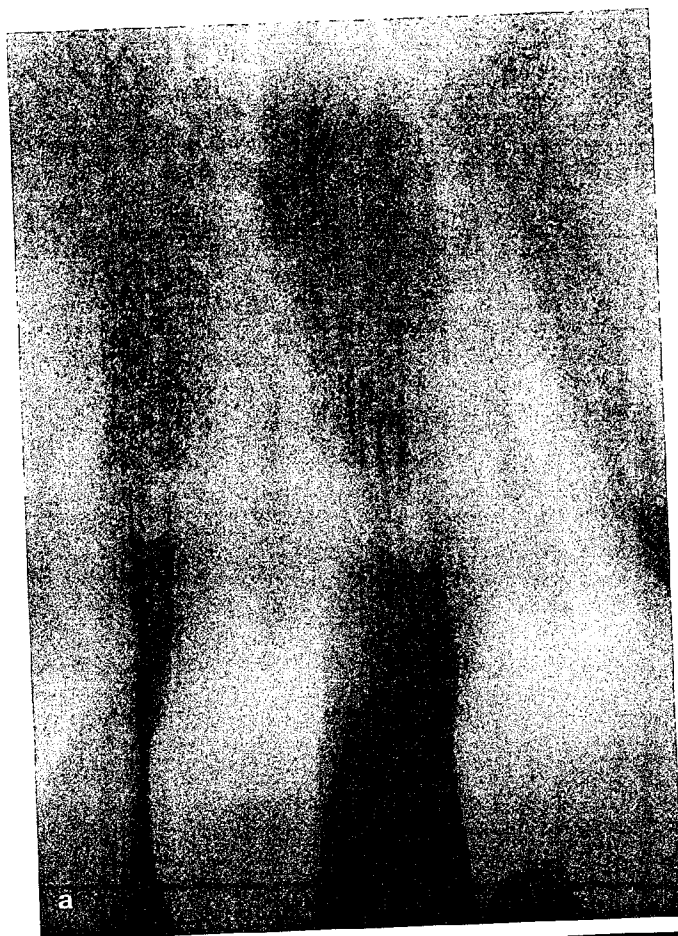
An upper right central incisor tooth that had acute irreversible pulpitis as a result of an extensive mesial crown:root fracture. (a) The pre-operative radiograph shows the extent of the fracture. (b) The tooth had a Ketac Fil interim restoration placed and this photo shows the interim restoration at a three-month review examination. There is slight discolouration of the material but it has provided the patient with an acceptable interim restoration whilst endodontic treatment was performed and until the tooth could be restored more definitively.
